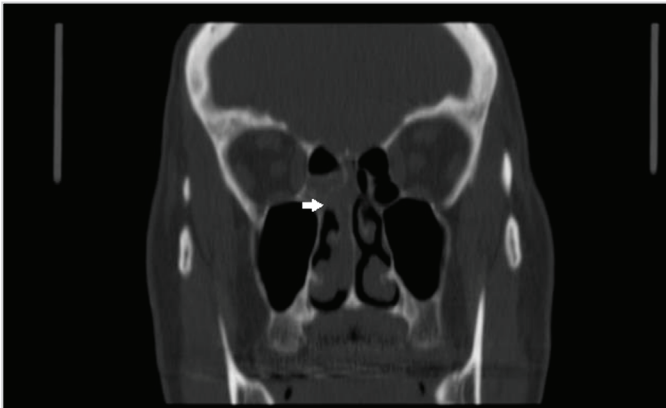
A polypoid mass in the right nasal cavity and mucosal thickening in the sphenoid sinus were observed in the coronal section of paranasal sinus CT
